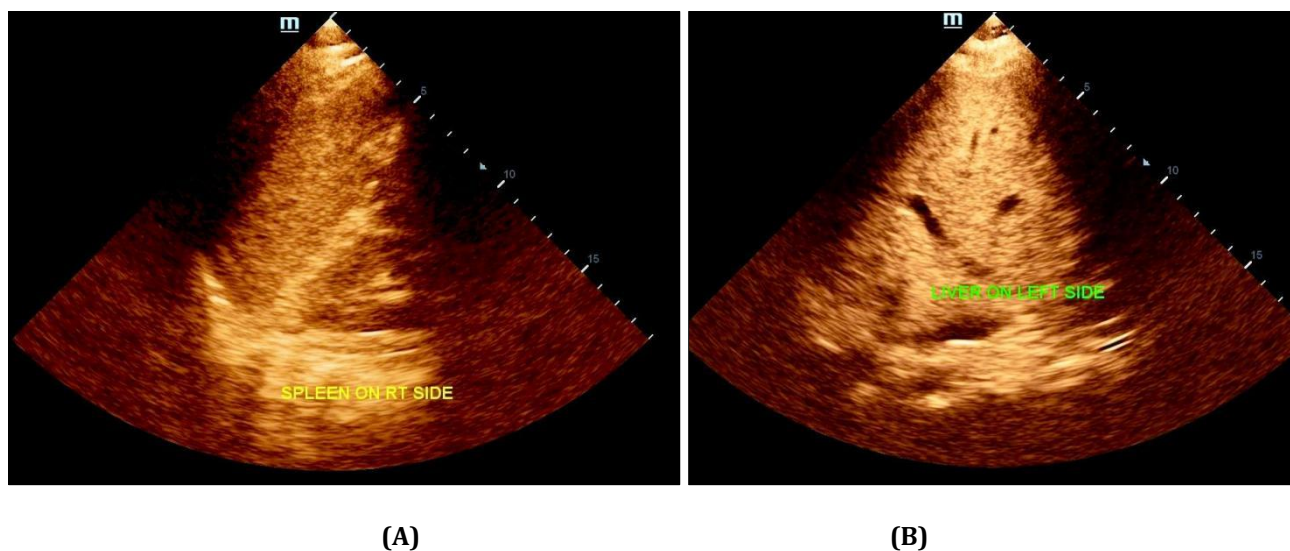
Situs Inversus - Ultrasound of abdomen. (A) Spleen on the right side; (B) Liver on the left side
